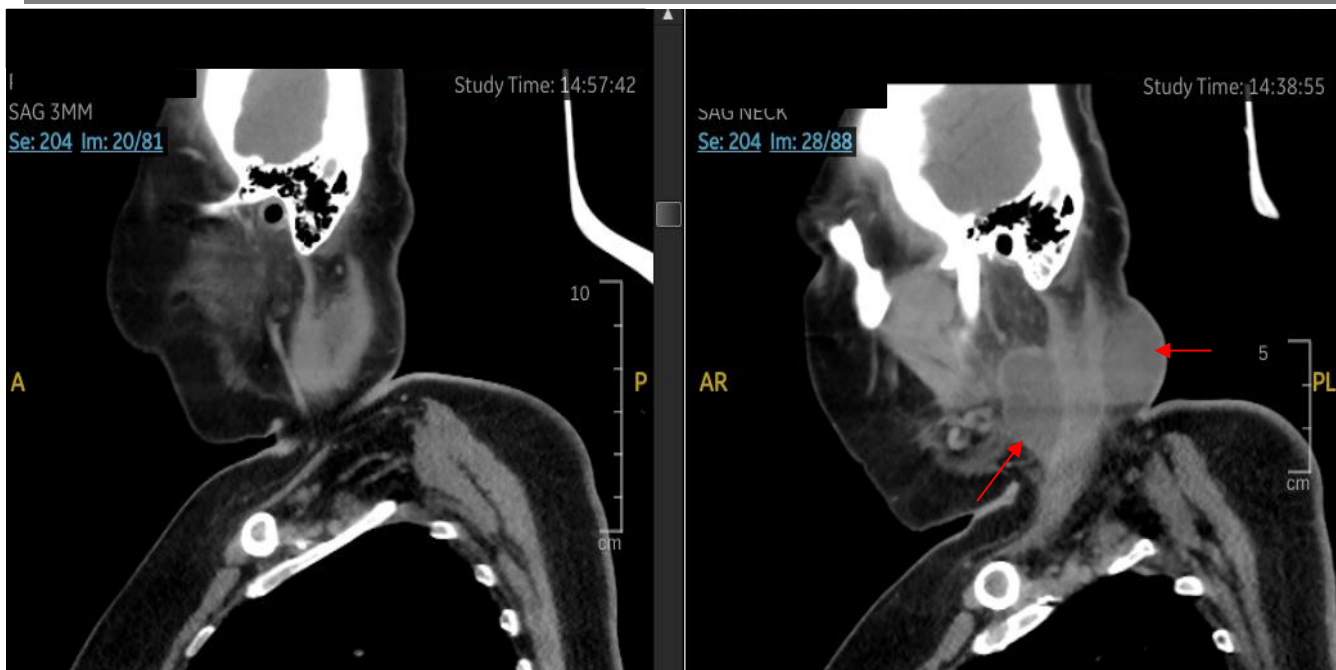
Sagittal view CT neck, previously inflamed cervical lymph nodes (left), progressed into suppurative nodes and deep neck abscess (right)
